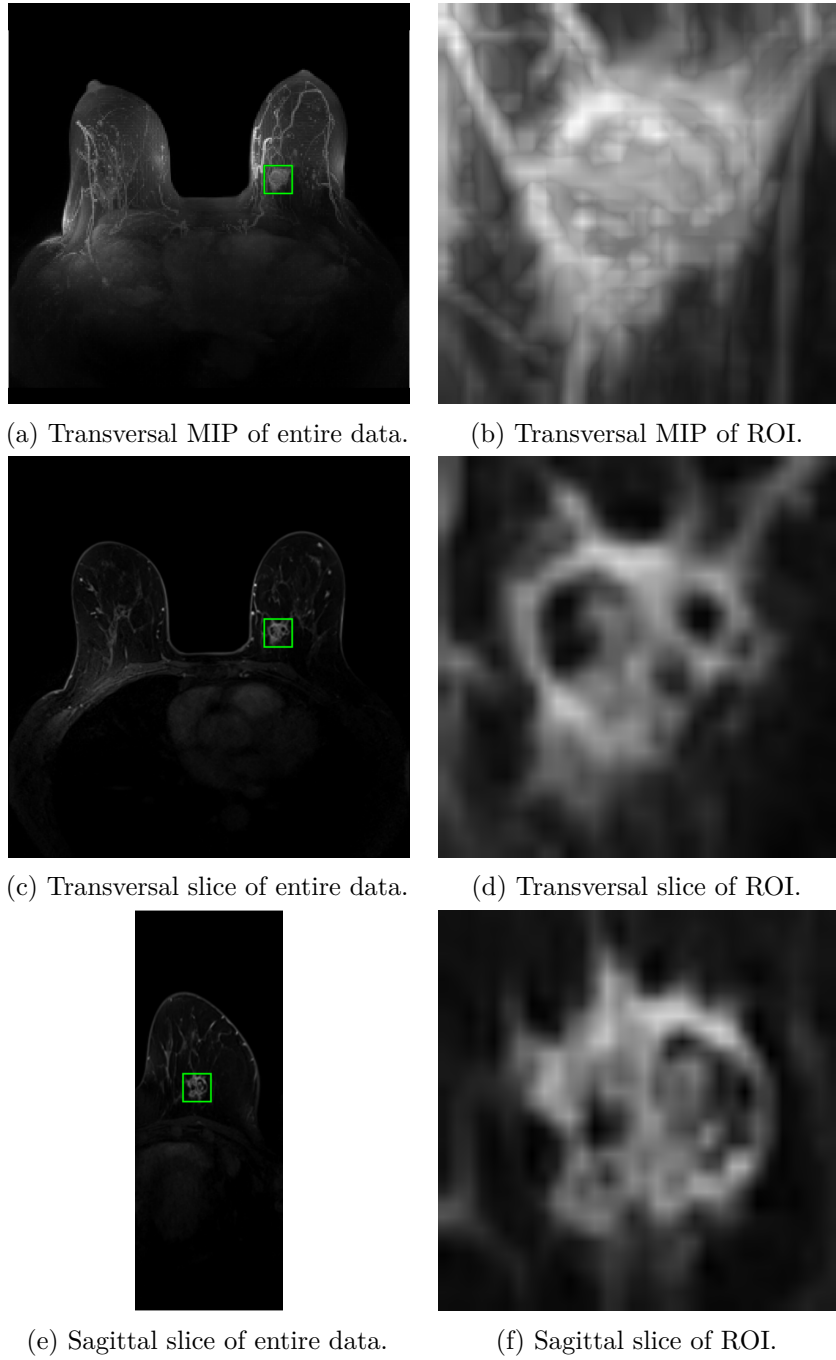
A DCE-MRI scan of a breast. The images on the left show the whole data set of the same breast, while the images on the right show the ROI, specified with the green rectangle, containing the same lesion. The first row is rendered using MIP viewed from the same direction (transversal). The last two rows are slice renderings viewed from two different directions (transversal, sagittal).
